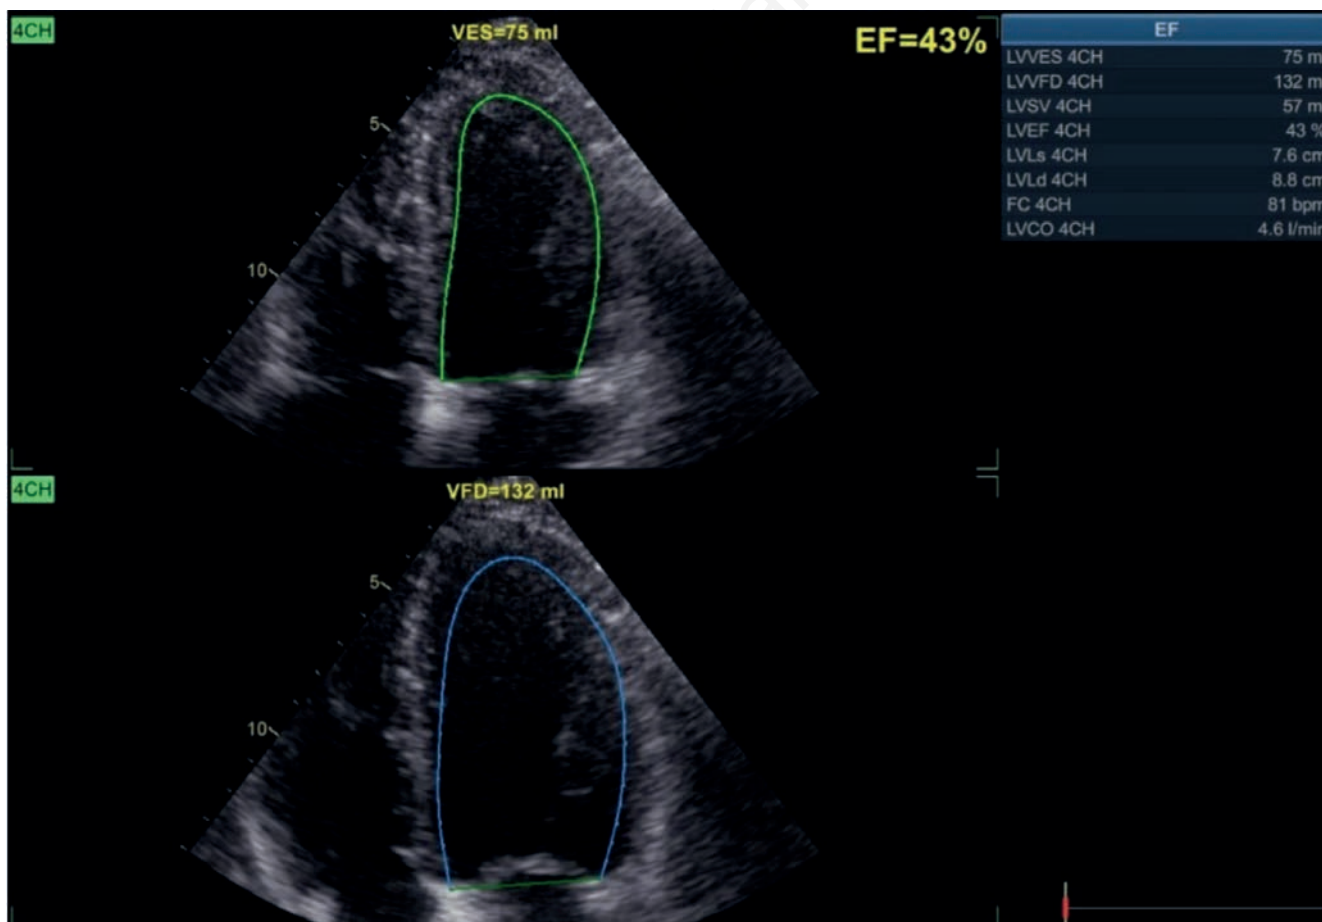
Bedside transthoracic echocardiography (TTE): ejection fraction calculated by biplane Simpson’s method estimated at 43%.
